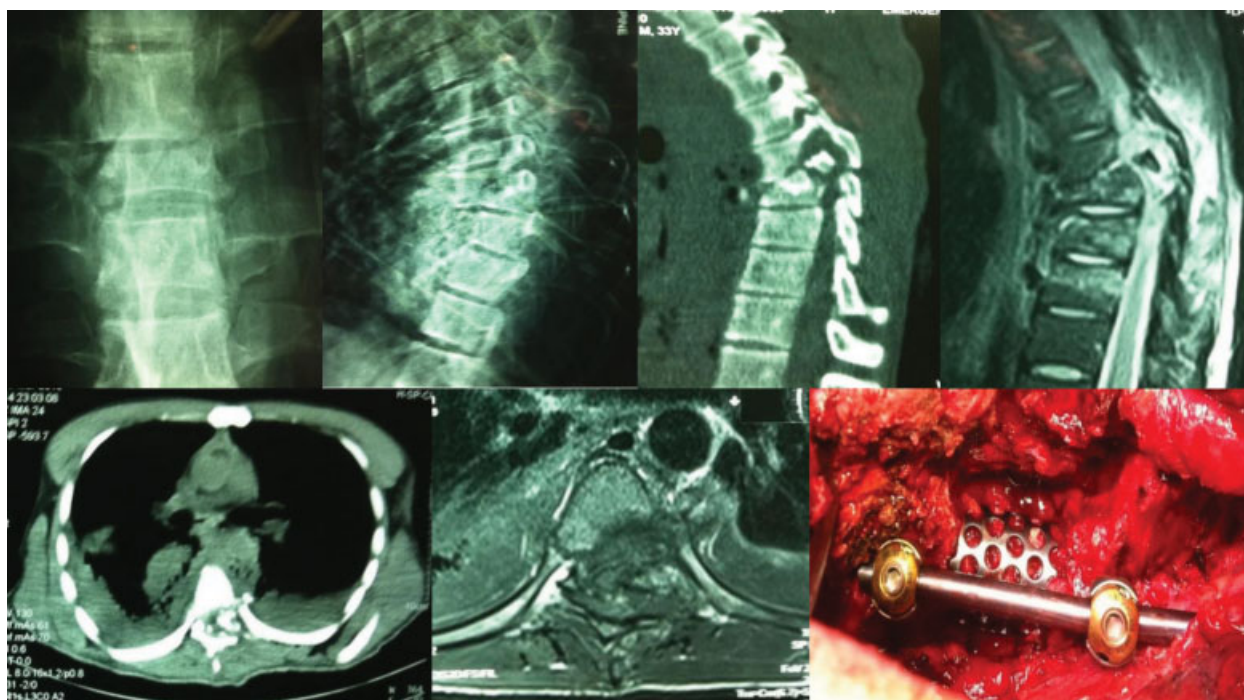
Walnut-spine Fracture dislocation of D6 vertebral body seen on sagittal MRI and axial CT scan of the dorsal spine. The operative photograph shows exposed thecal sac.
